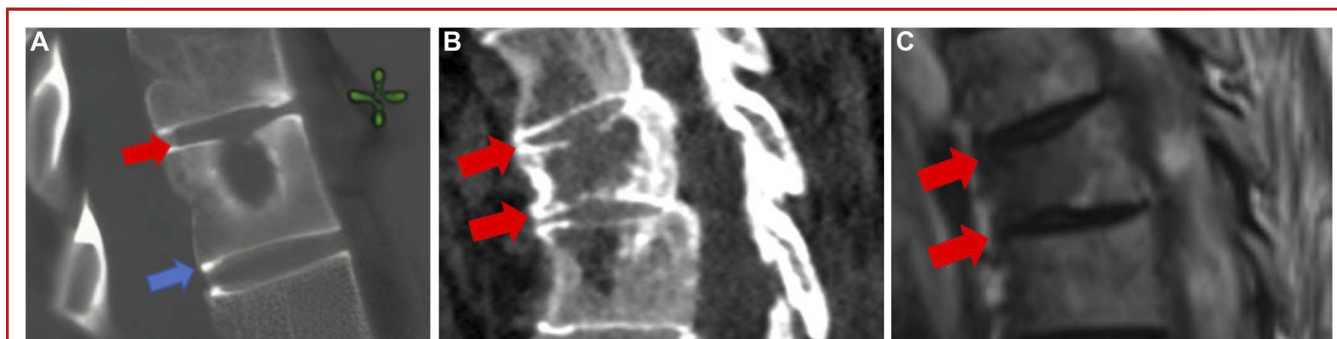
A, An example of T11 superior EP disruption from the tumor (red arrow) and intact inferior EP (blue arrow). T5 superior and inferior EP disruption from the tumor (red arrows), B, computed tomography scan and C, MRI. All previous radiation. EP, endplate.
